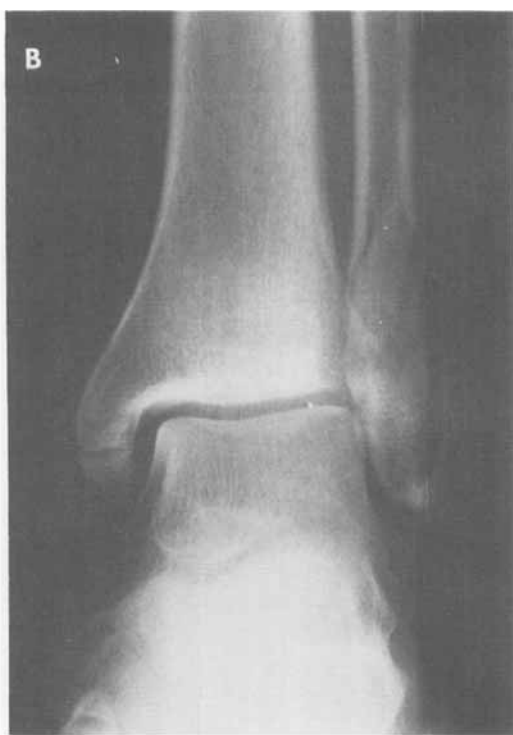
Roentgenograms of a displaced fracture of the anterior colliculus in a supination-external rotation lesion: A) lateral view; B) anteroposterior view; C) external rotation stress view revealed no widening of the medial mortise; and D) at 2 months, the fracture line is visible and the edges of the fragments are sclerotic.
